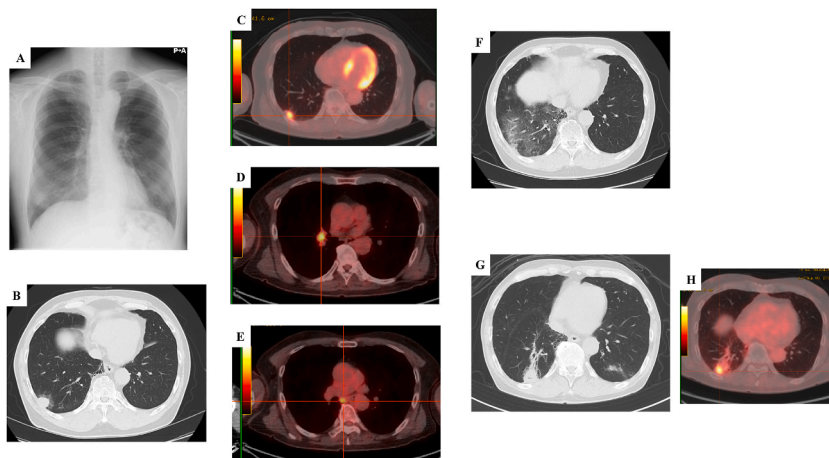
Chest X-ray on initial diagnosis revealed a primary mass in the lower lung field of the right lung (A). Chest computed tomography was performed at the following time points: (B) on initial diagnosis, (F) after concurrent radiotherapy plus chemotherapy, and (G) on recurrence. 18-Labeled fluorodeoxyglucose (FDG) positron emission tomography on initial diagnosis revealed abnormal accumulation of FDG in the right lower lobe mass (C) and hilar (D) and mediastinal lymph node (E). FDG positron emission tomography performed at recurrence revealed abnormal accumulation of FDG in the right lower lobe mass (H).
